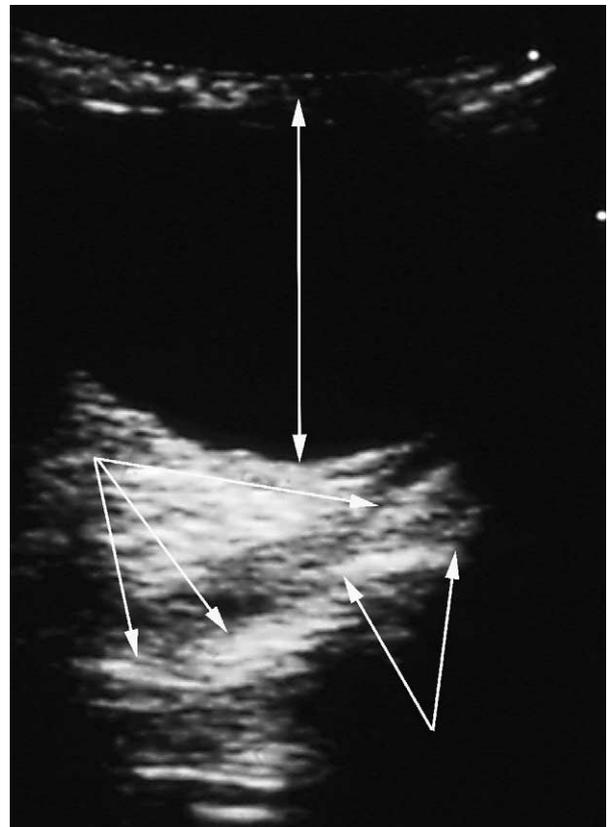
Ultrasound image of an orbital floor fracture. The double arrow shows the eyeball. The lower arrows show on the dislocated fragment. The upper arrows show the unfractured area of the orbital floor.
